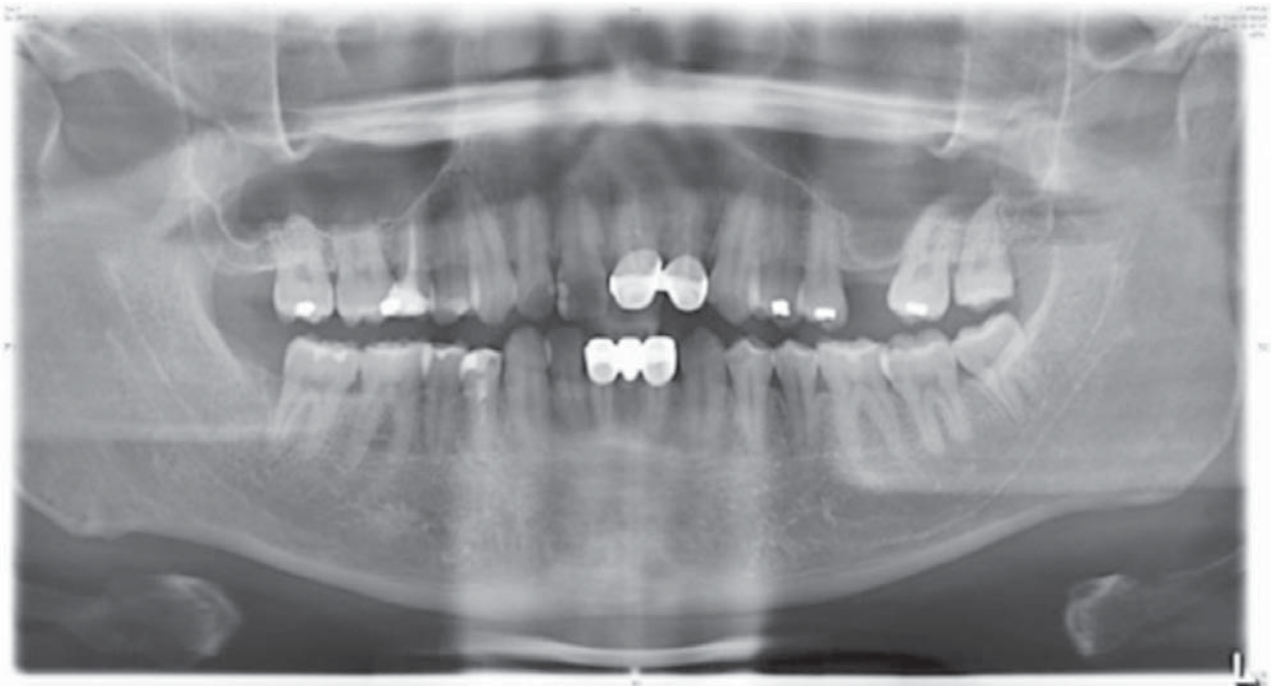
Initial radiographic assessment. Ridge height of left first molar was less than 2 mm as seen in the initial radiograph.
